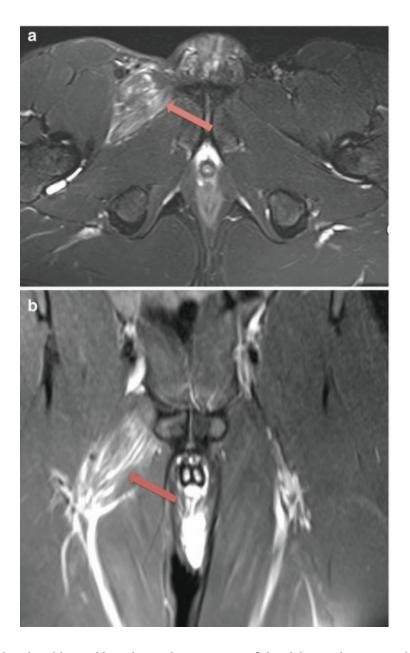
A 24-year-old male athlete with an intrasubstance tear of the right pectineus muscle. (a) Axial, and (b) coronal short tau inversion recovery MRI show right pectineus muscle is enlarged and displays intra-substance high signal intensity interspersed within muscle fibers (arrow), in keeping with muscle strain. The proximal attachment of the right pectineus is intact
